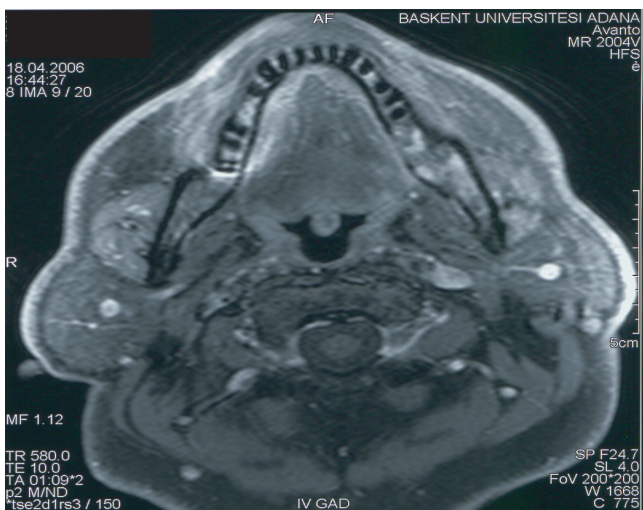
Magnetic resonance imaging view
